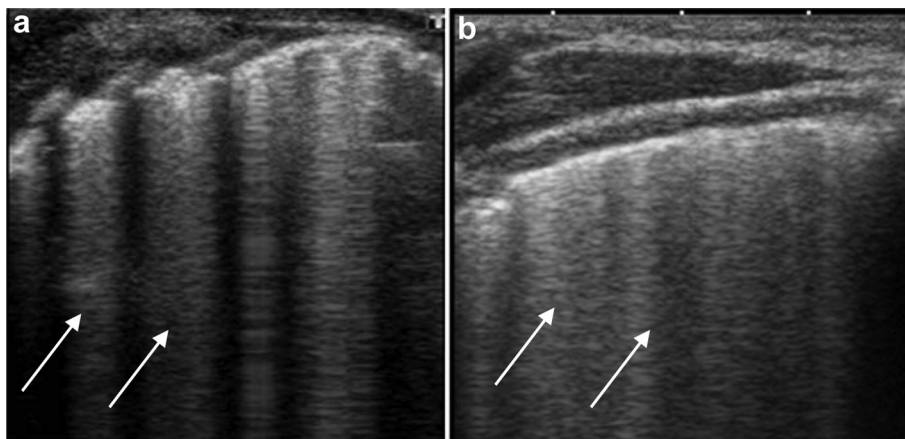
Ultrasound images of alveolar interstitial syndrome. (a) Interstitial edema with comet tail artifacts 7 mm apart (*arrows*). (b) Alveolar edema with wide comet tail artifacts <3 mm apart (*arrows*).
